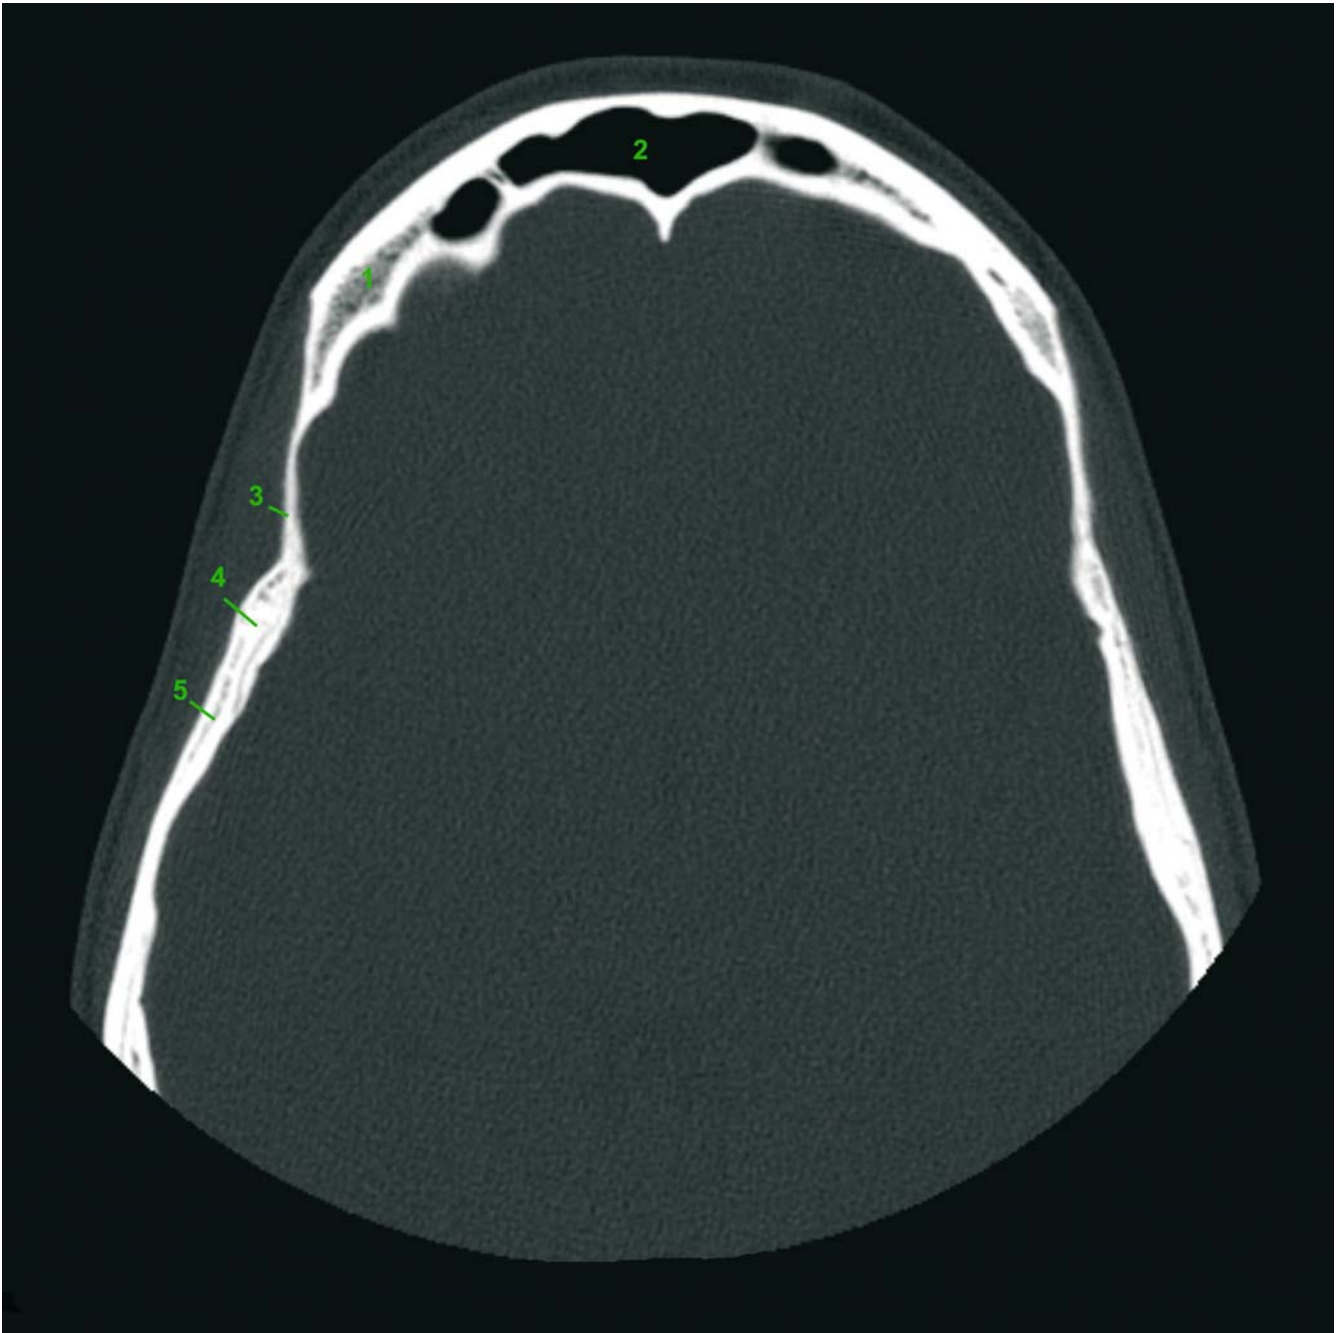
Axial CT slice 1 (patient K.C.). 1 Frontal bone; 2 Frontal sinus; 3 Sphenoid bone; 4 Sphenosquamosal suture; 5 Temporal bone
